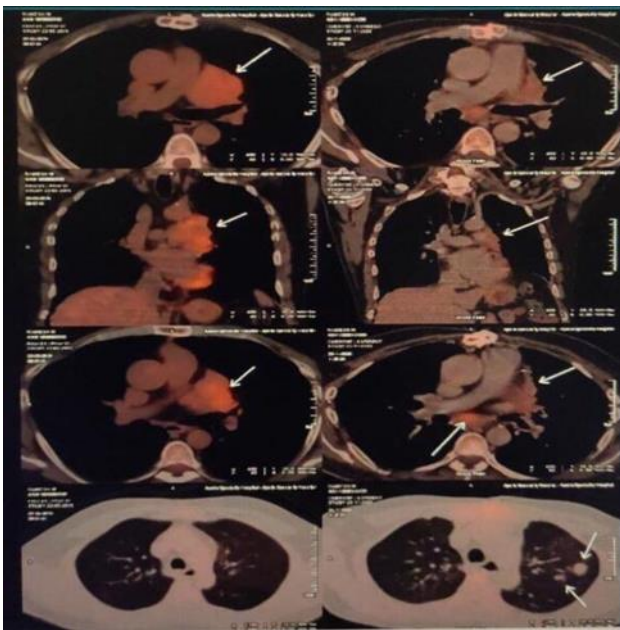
PET-CT whole body showing features suggestive of infiltrative thymoma.
